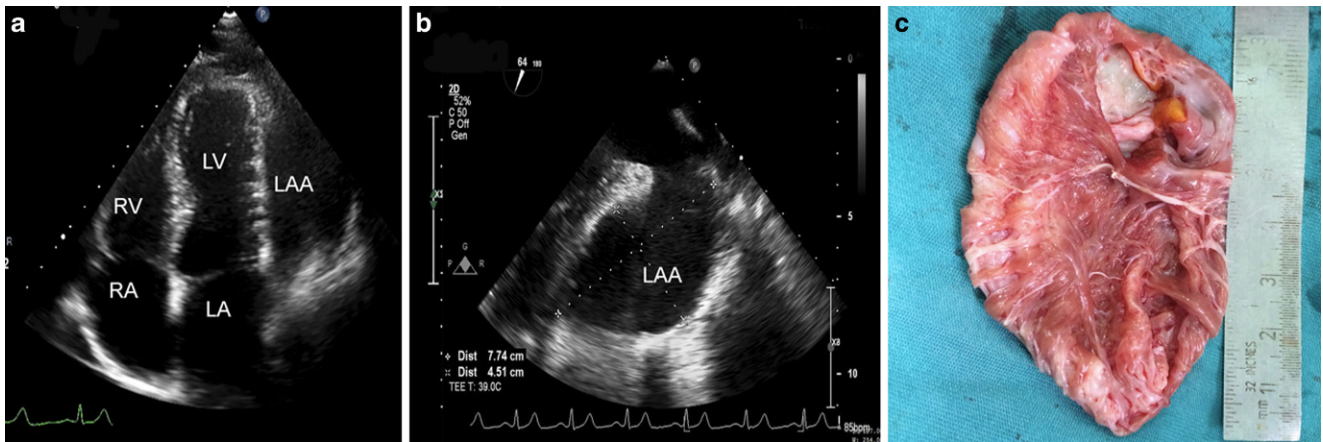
a Transthoracic four chamber echocardiogram showing the aneurysmal left atrial appendage with compressive effect on left ventricle, b Transoesophageal echocardiogram obtained at mid-oesophageal level in 60° showing the left atrial appendage aneurysm, c Intraoperative image showing the resected left atrial appendage aneurysm, LA left atrium, LAA left atrial appendage, LV left ventricle, RA right atrium, RV right ventricle
